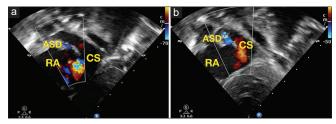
Echocardiogram in subcostal view showing (a) very tiny atrial septal defect with right-to-left shunt and dilated coronary sinus, (b) after wire stenting of atrial septal defect wider jet of color flow is seen along with metal artifact due to wire across atrial septal defect
